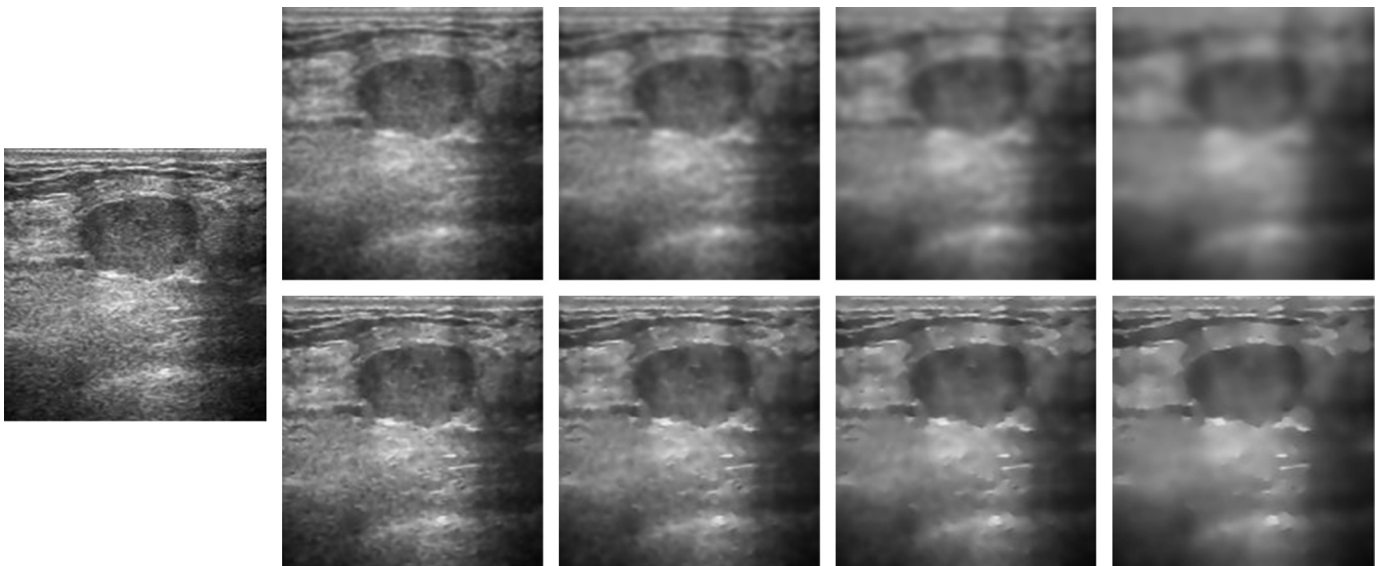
Comparisons of speckle reduction by different filtering schemes. (Left) An ultrasound image of breast tumor. (Top row) Speckle reduction by Gaussian filtering. From left to right, the noise in the image is gradually smoothed out as the variance of Gaussian kernel increases, but the edges of breast tumor are also blurred. (Bottom row) Speckle reduction by SRAD filtering. As the scale increases, SRAD both reduces speckle noise and preserves the tumor boundaries.
